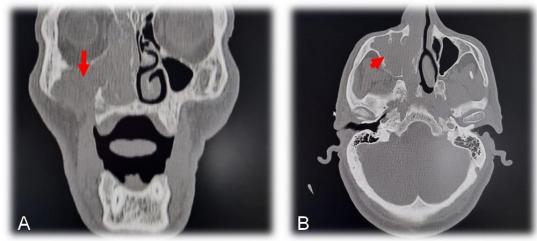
(Coronal (A) and axial (B) CT scans showing a heterogeneous tissue lesion process filling the right maxillary sinus, nasal cavity, ethmoid cells, and frontal and sphenoidal sinuses on the same side.)
